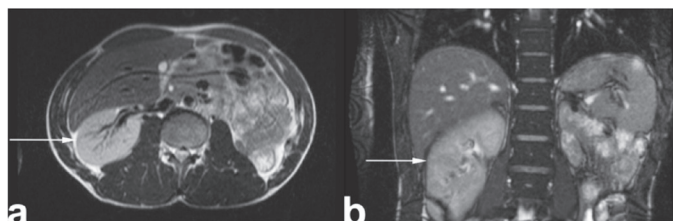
a) Axial and, b) coronal T2 weighted image magnetic resonance imaging images shows compensatory right kidney and left kidney fossa empty (arrows)
